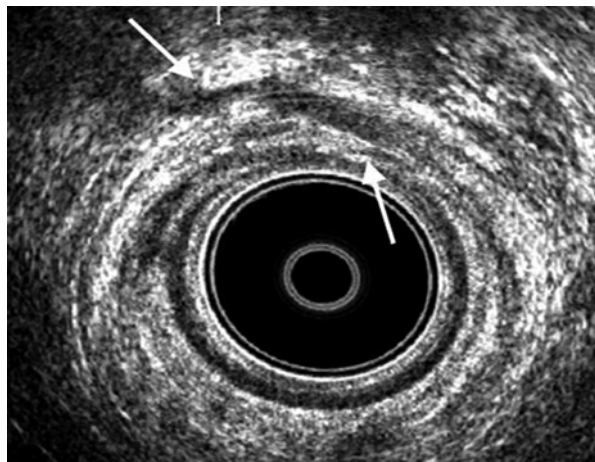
3D endoanal ultrasound. Anterior combined internal and external anal sphincter lesion due to childbirth trauma. On the reconstructed coronal plane, the damage involves the full length of the anal canal in (a) and the superior 2/3 in (b)
